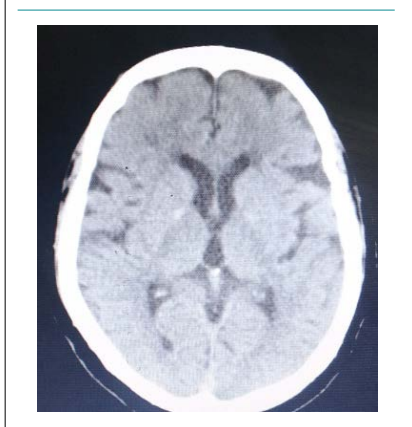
CT Image 2 Air Absorbed After Treatment
